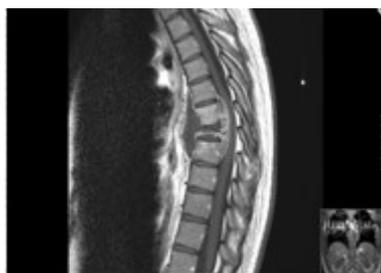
Magnetic resonance image (MRI) showing destruction of T12/L1 vertebrae
